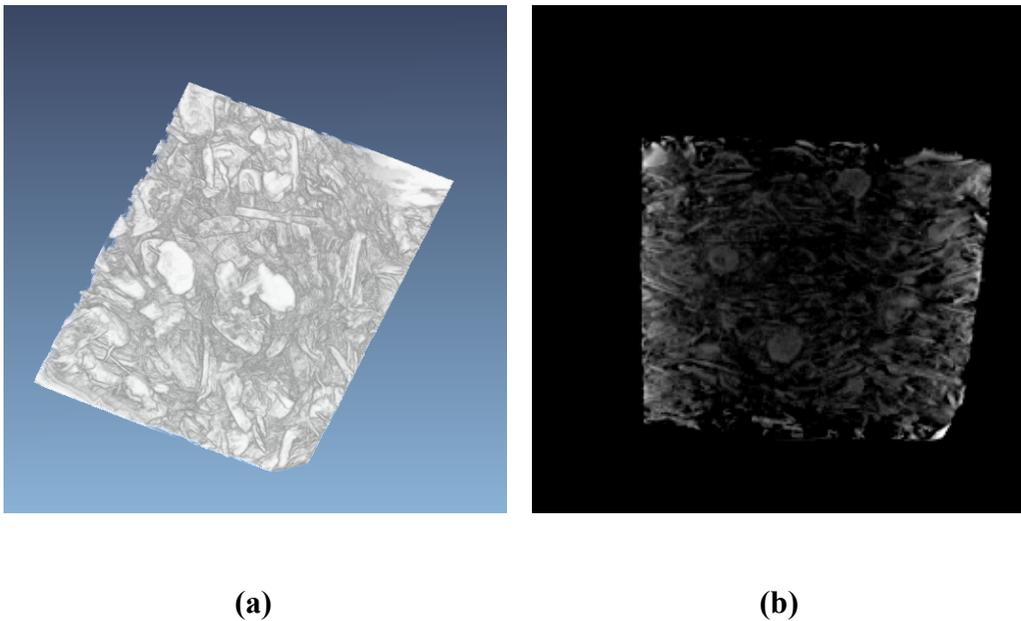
Figure C-3: CT scans of intruded filter samples: (a) 3D view of pores reproduced as solid images; (b) reconstructed pore space, pores on the edges were intruded better than pores in the middle and thus were more visible in imaging
